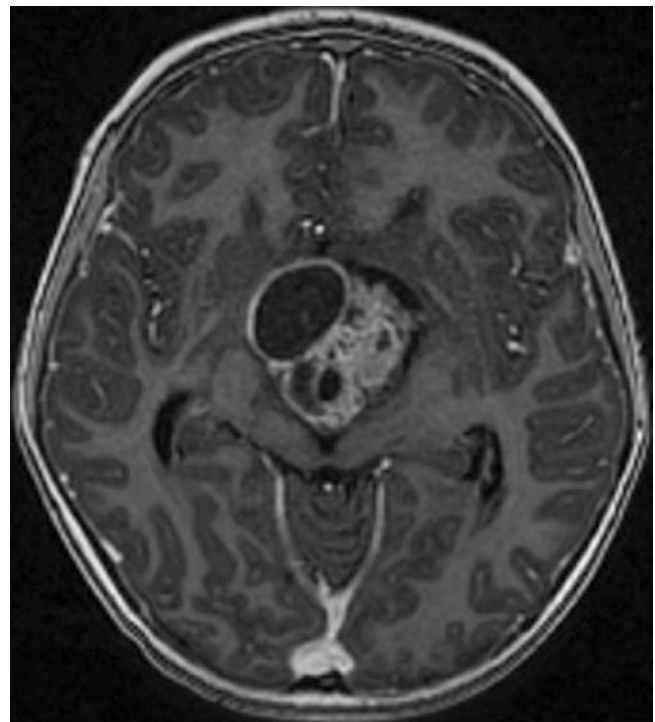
Craniopharyngioma. Axial post-contrast T1-weighted MR image demonstrates enhancement of the solid part of the tumour and rim enhancement of the cystic components
